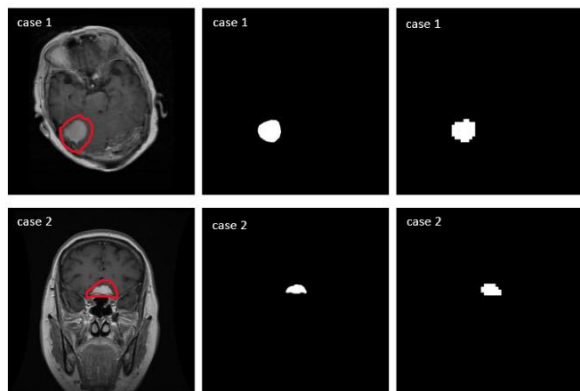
Outcomes of the segmentation of multiple brain metastases for cases 1 and 2. The raw MRI is displayed in the first column, the manual segmentation is presented in the second column, and the HNN P system prediction is presented in the final column.
